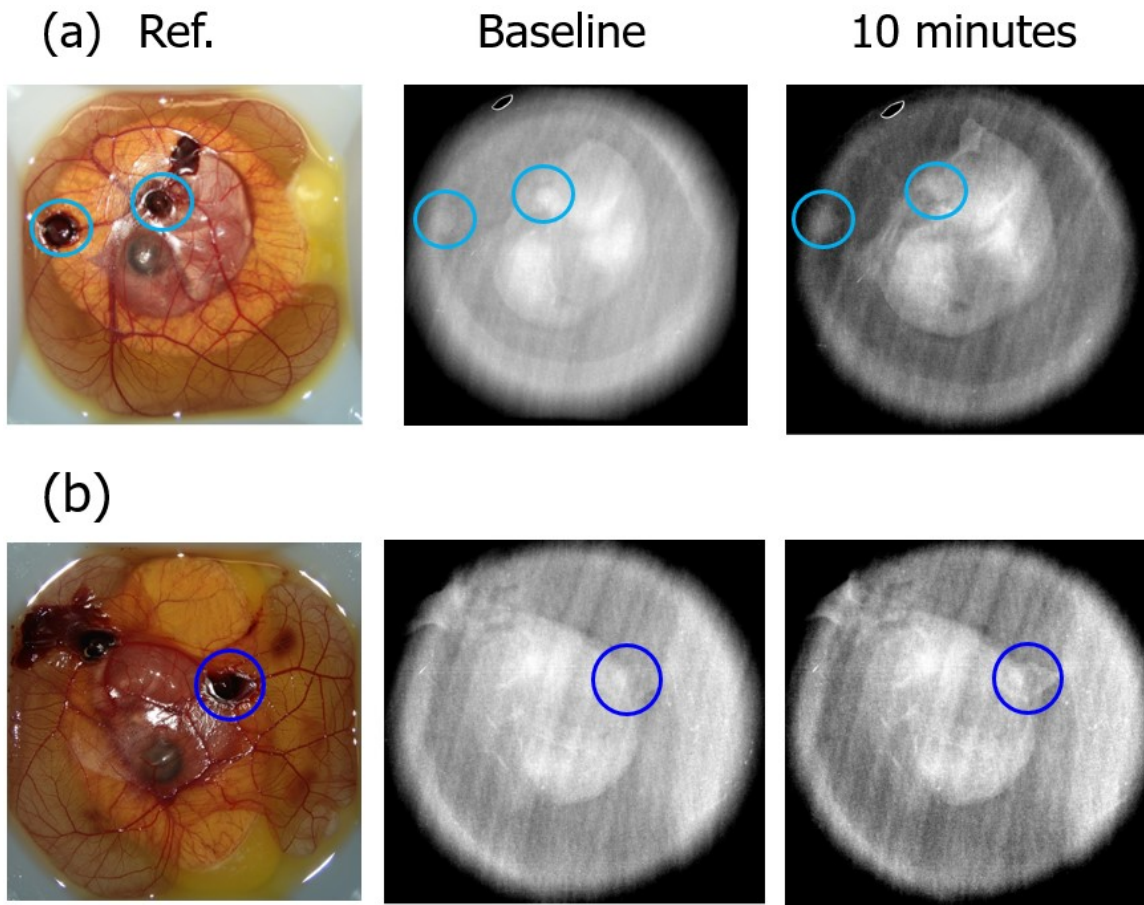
Comparison of Omnipaque® (GE Healthcare) and NSC (long hexagonal structure) in producing contrast enhancement in a CAM tumor model. The CAM models were implanted with HT1080 cell line tumors that were grown to a diameter of about 1 cm before being imaged (see Ref. images). a) The CAM was implanted with two tumors (light blue circles) at baseline (preinjection), with the right tumor showing evidence of peritumoral neoangiogenesis. X-ray imaging did not clearly visualize the tumor or hemorrhage. 10 minutes post-IV injection of Omnipaque® produced contrast enhancement and clearly distinguishable tumors as well as highlighting the area of neoangiogenesis. b) Similar findings were also seen in with CAM tumor models with IV injection of NSC.
